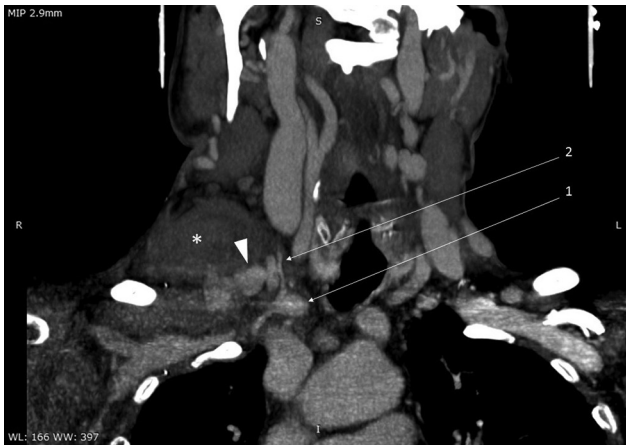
Maximum intensity projection computed tomography angiography image showing the right subclavian artery (arrow 1) and the inferior thyroid artery (arrow 2) with a large hematoma (asterisk) with pseudoaneurysm (arrowhead).
